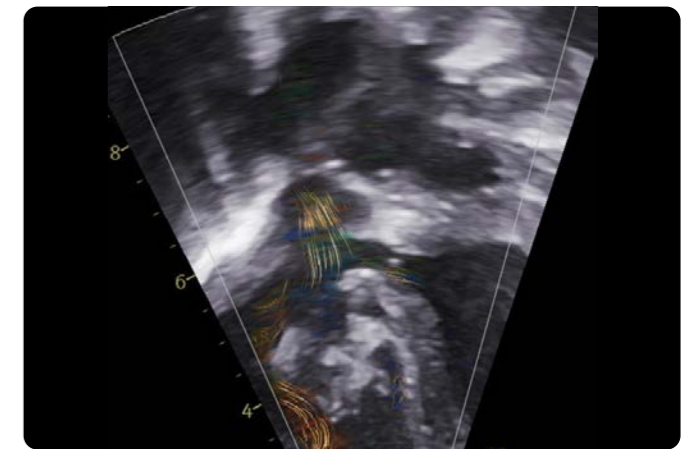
Subcostal short axis view in a similar plane to Image 1, showing blood flow both from the LV to the aortic valve, and from the RV to aortic valve. Even though this patient had a subaortic VSD, and should have demonstrated normal oxygen saturations, the patient's anatomy resulted in streaming of blood with deoxygenated blood from the RV entering the aorta and causing lower oxygen saturations. This was not well appreciated with standard color Doppler imaging.
